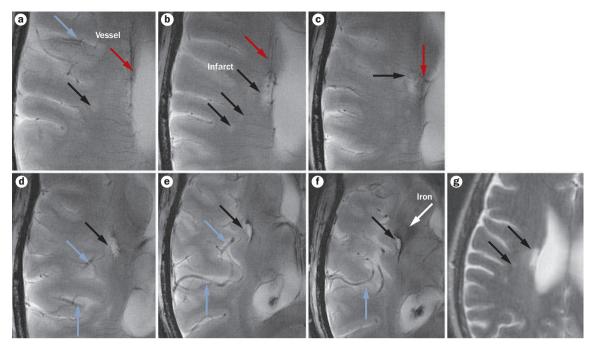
High resolution 8-T gradient gadolinium-enhanced echography slices (in-plane pixel size 195  $\mu$ m). a-f | Vascular supply to the lacunar infarctions and vascular patterns in the infarcted region. Black arrows, infarct sites. Red arrows, small vessel ending within low signal intensity foci in the lacunar infarction. Blue arrows, branches of the cerebral artery supplying infarcted areas. White arrow, larger area of low signal intensity suggestive of iron deposits that extends beyond infarction into the basal ganglia. Iron deposition in brain parenchyma may represent blood–brain-barrier breakdown associated with microvascular disease and microinfarcts. g | Clinical T2-weighted image of the infarcted area (indicated by black arrows), obtained with 1.5-T MRI. Modified with permission from Novak et al.  $^{53}$
